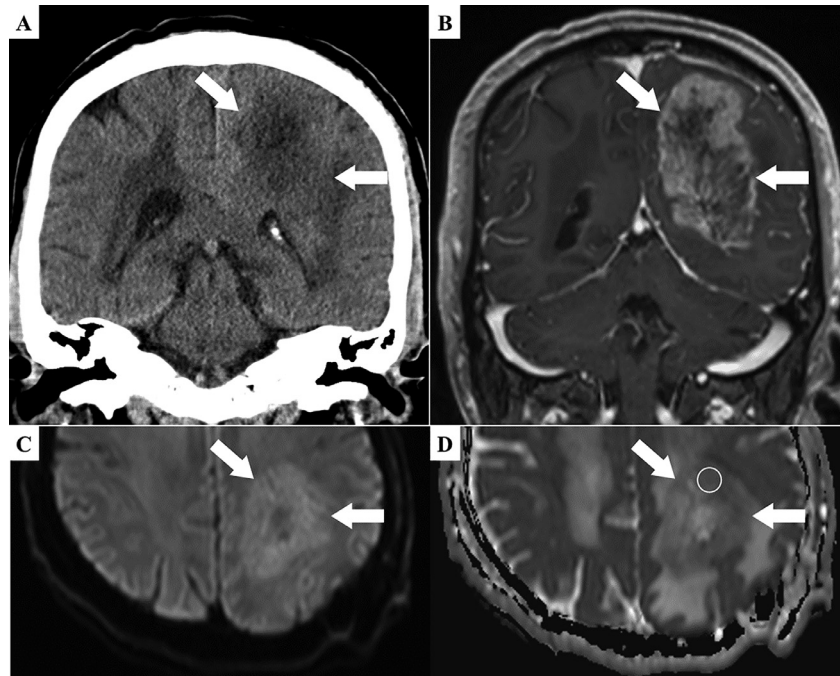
Imaging obtained after discontinuation of steroid administration. (A) Non-contrast-enhanced CT at 9 days after the first day of steroid discontinuation shows decreased lesion density (arrows). (B) Contrast-enhanced T1-weighted MRI at 12 days after the first day of steroid discontinuation shows recurrent contrast enhancement (arrows). (C, D) DWI at 12 days after the first day of steroid discontinuation shows obscure diffusion restriction (arrows), with an ADC of $0.989 \times 10^{-3} \text{ mm}^2/\text{s}$ (circle).
